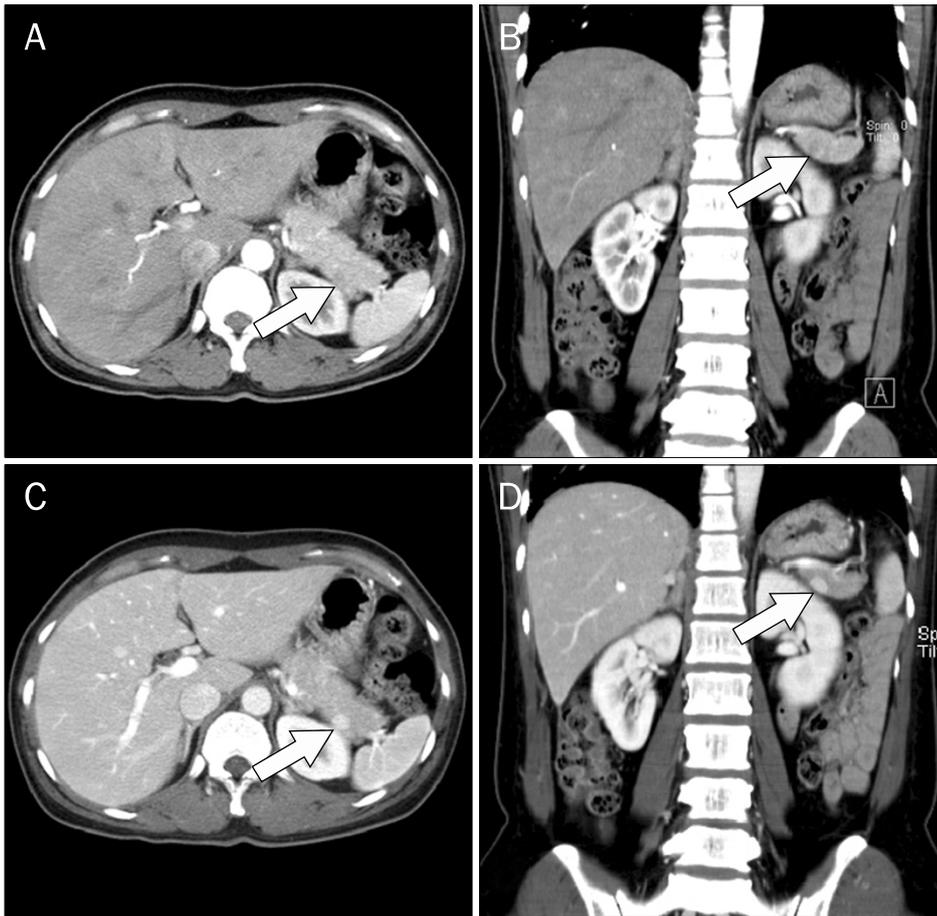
CT with contrast enhancement of the patient. A 1 cm-sized, oval-shaped, and well-enhanced mass was detected in the tail of the pancreas. (A, B) The pancreatic tail mass exhibited a different enhancement pattern in the arterial phase compared to that of the spleen (arrows). (C, D) In the delayed phase, the pancreatic mass was highly enhanced and distinguished from the surrounding pancreatic parenchyma (arrows).
